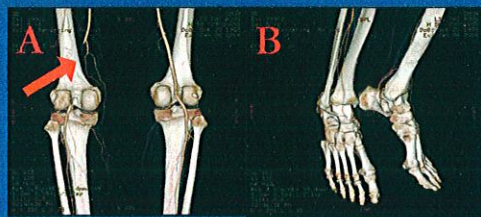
CT disclosed occluded distal left SFA and L poplitea artery (A) with patent left infrapopliteal arteries (B).
